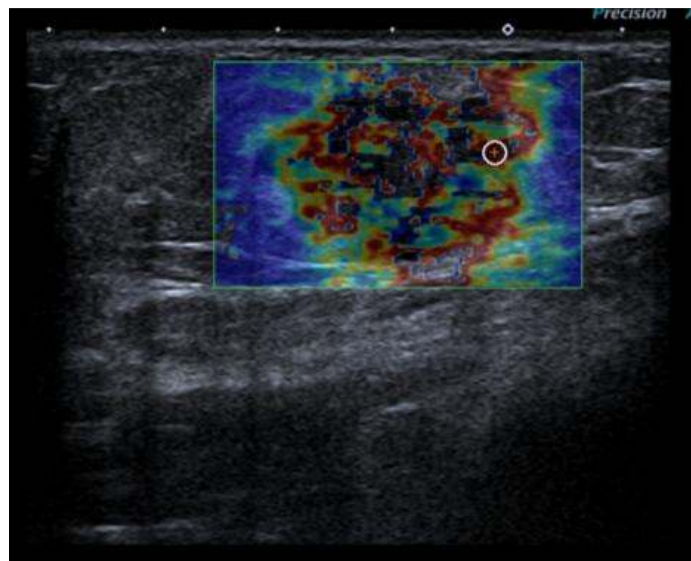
Shear wave ultrasonographic findings of IMLN; mean elasticity value was 129.5 ± 26.2 kPa
